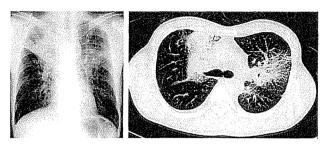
Chest X-ray (left) and CT (right) taken in December 2011 show infiltrative shadows in the bilateral upper lobes.
